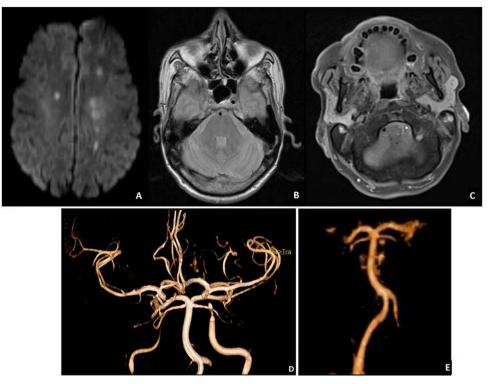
Subacute brain MRI and MR angiography. (A) Diffusion-weighted imaging showing internal borderzone infarcts bilaterally. (B and C) T1-weighted fat-suppressed images. Intramural haematoma of both internal carotid arteries (B) and left vertebral artery (C) are visible. (D and E) MR angiography with typical pencil-like occlusion of internal carotid arteries and the left vertebral artery.
